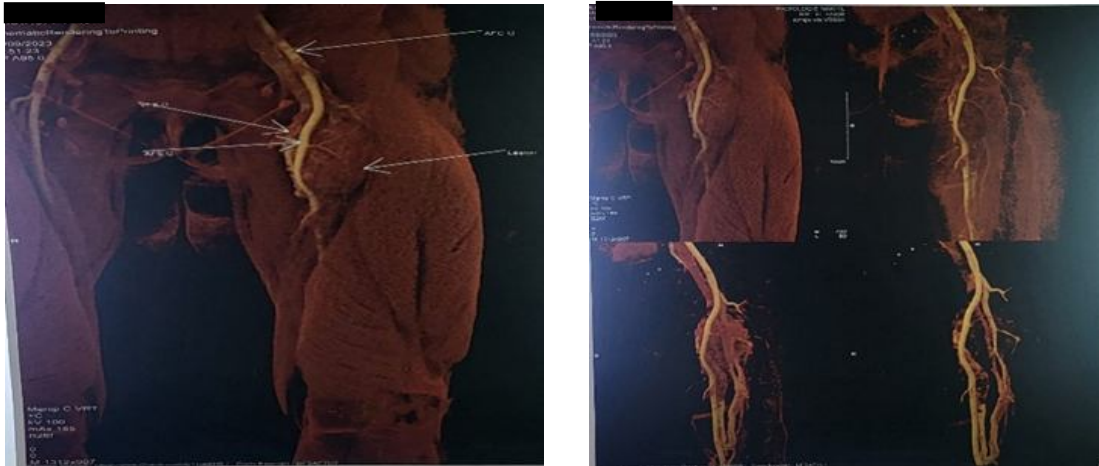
MRI angiography: endovascular tumour process in the left femoral vein, suggesting in the first instance a leiomyosarcoma involving the femoral artery
